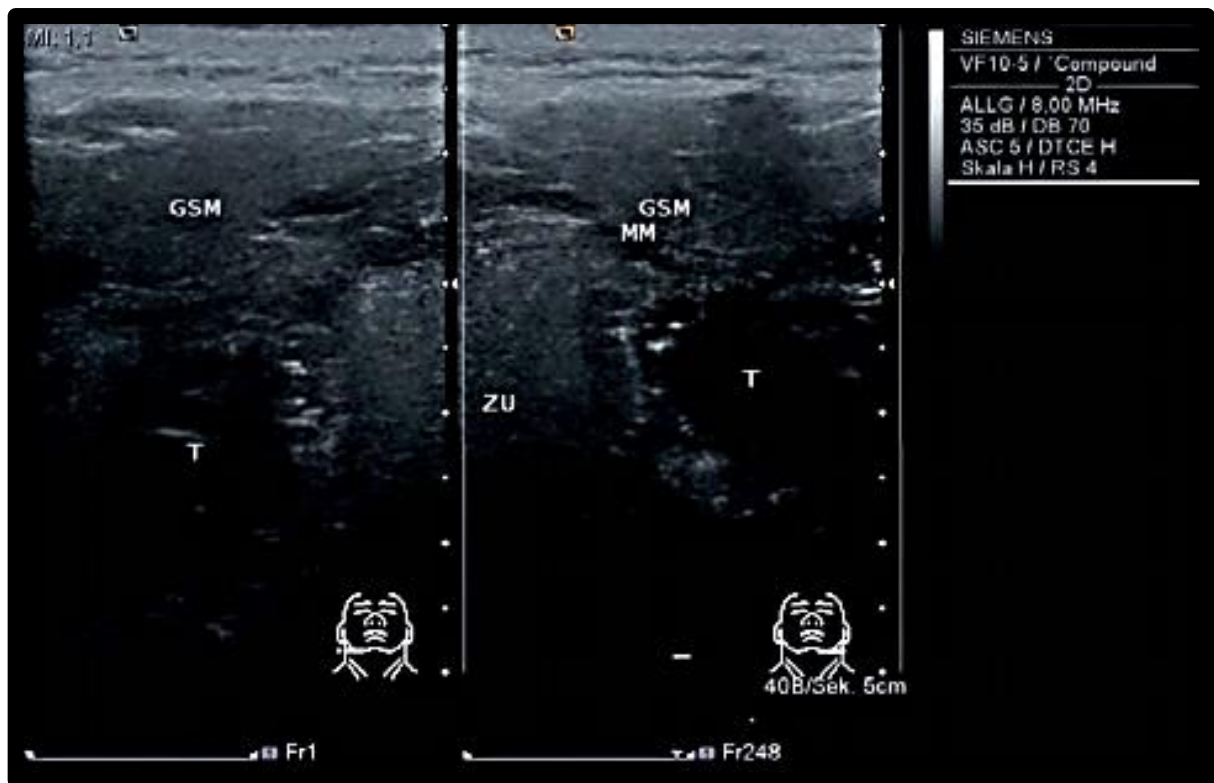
Split screen (submandibular region), acute tonsillitis: The two tonsils (T) are enlarged with blur margins without clear distinction of surrounding tissue, other structures mylohyoid (MM), submandibular gland (GSM) and tongue (ZU) are visible. Radiograph extracted from Heinrich, Johannes & Alessandro (2013).
